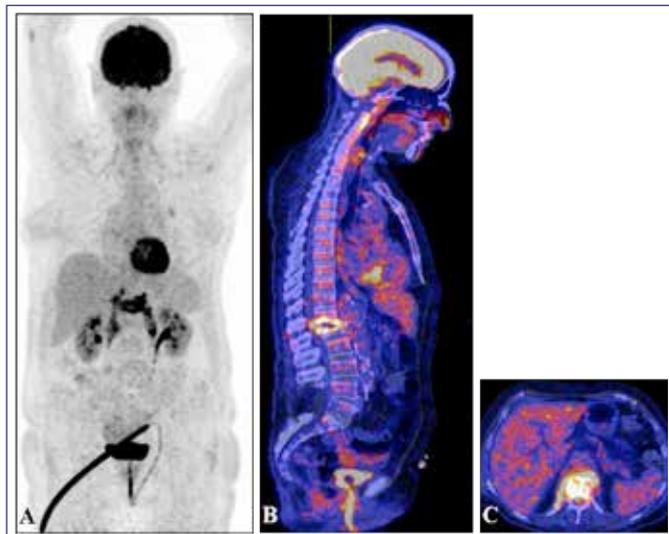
$^{18}\text{F}$ -FDG PET/CT of a patient with spondylodiscitis and involvement of the psoas muscles.
